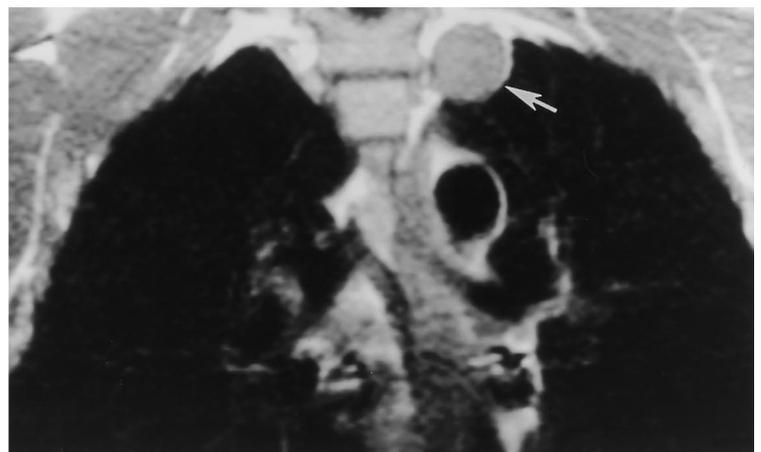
(Left) PA chest radiograph and (right) unenhanced T<sub>1</sub>-weighted coronal MRI in an asymptomatic 24-year-old man. A schwannoma (arrow) manifests as a 3-cm spherical posterior mediastinal mass with homogeneous intermediate-signal intensity without evidence of foraminal or intraspinal tumor extension.
